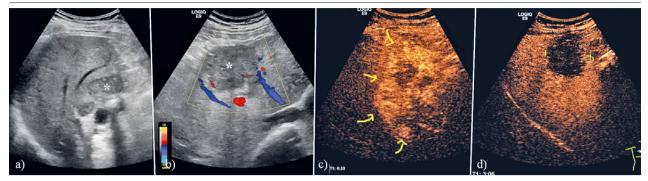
Gallbladder carcinoma: a) grayscale (asterisk); b) colour Doppler (asterisk); c) CEUS, arterial phase (arrows); d) CEUS, venous phase.
